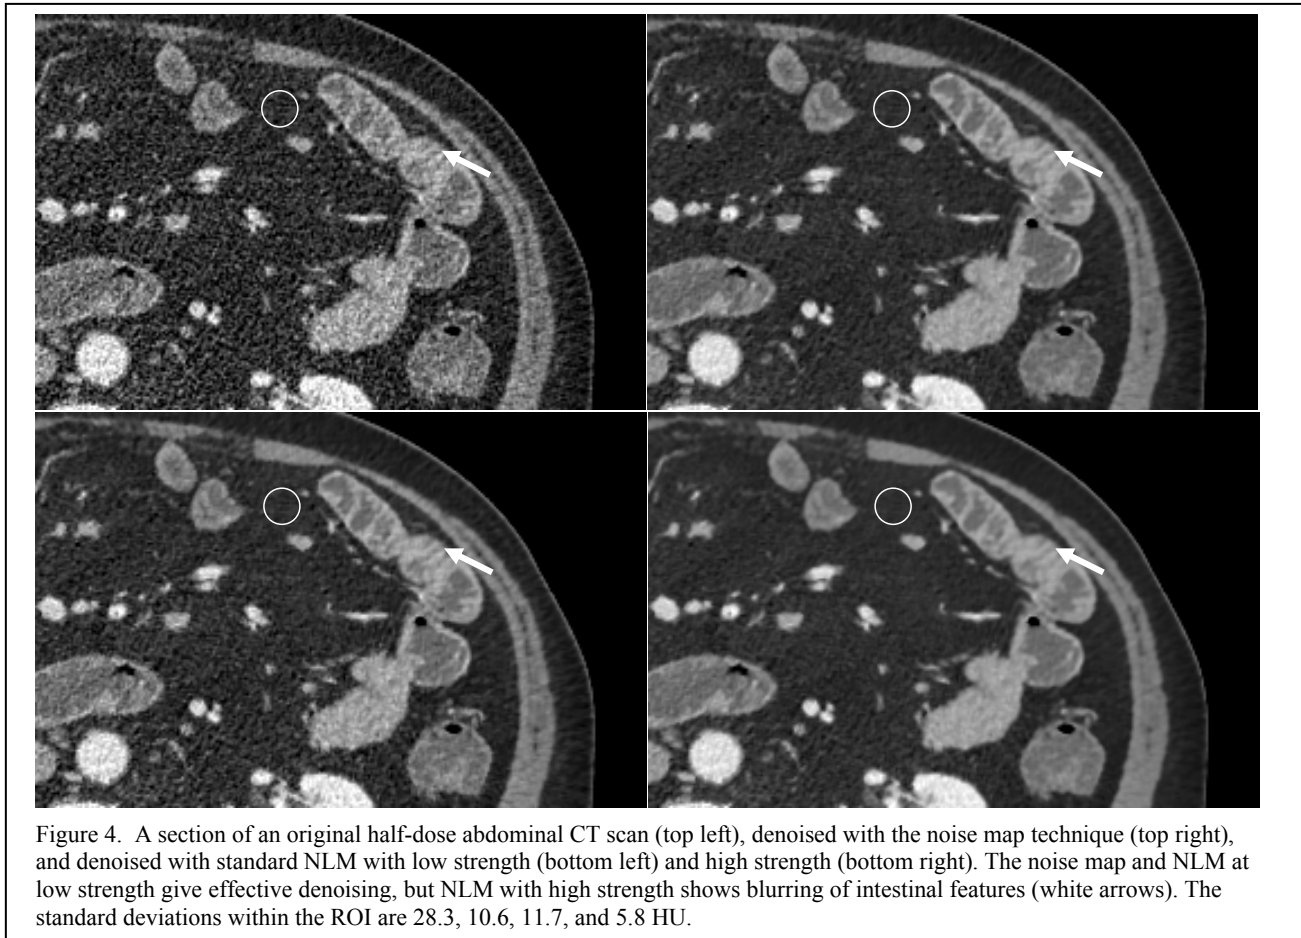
A section of an original half-dose abdominal CT scan (top left), denoised with the noise map technique (top right), and denoised with standard NLM with low strength (bottom left) and high strength (bottom right). The noise map and NLM at low strength give effective denoising, but NLM with high strength shows blurring of intestinal features (white arrows). The standard deviations within the ROI are 28.3, 10.6, 11.7, and 5.8 HU.
